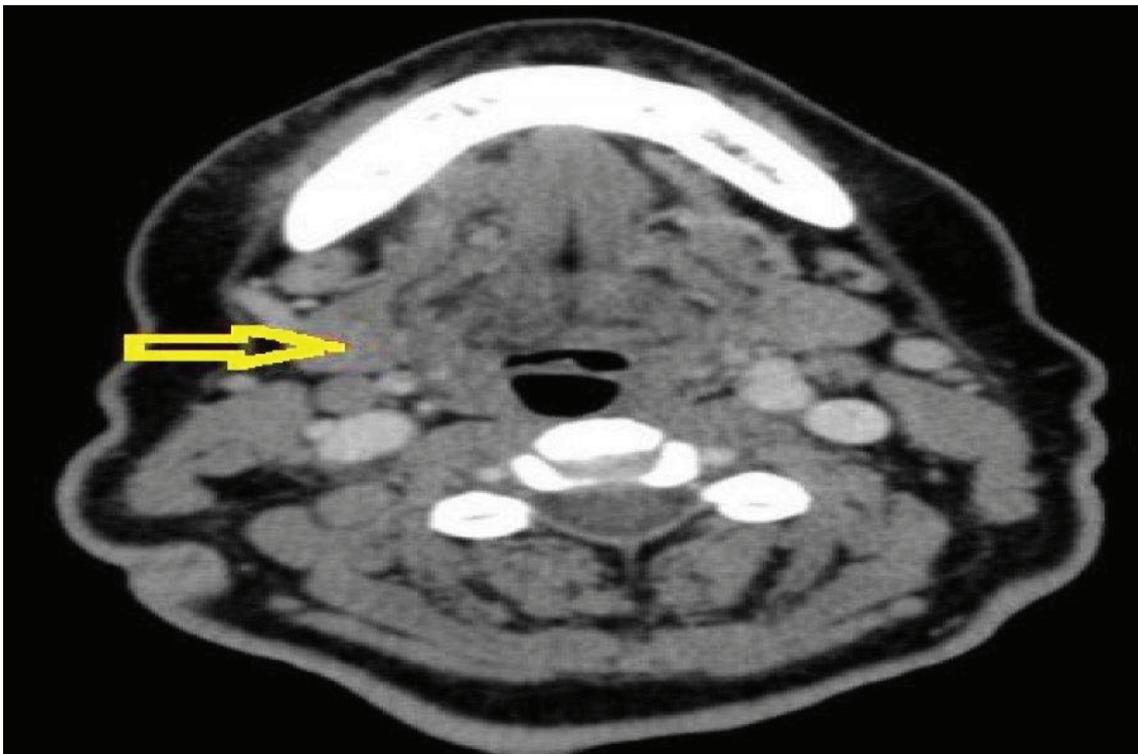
This computed tomography section shows suspected involvement of submandibular gland with primary tumour.
